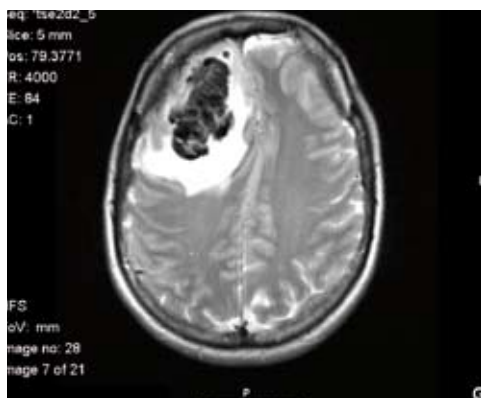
Cerebral - MRI angiogram showing thrombosis of the anterior third of the superior sagittal sinus with venous frontal infarcts with an hemorrhagic content.
